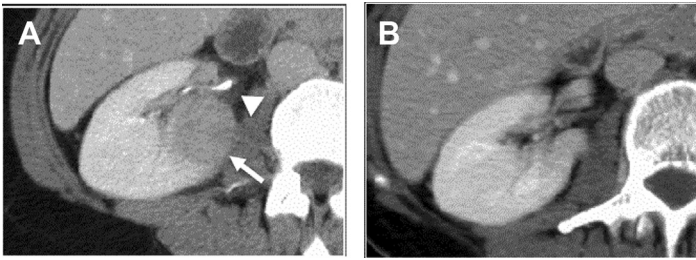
(A) Axial contrast-enhanced CT image in a patient with flank pain shows a focal rounded masslike abnormality (*arrow*) with mild stranding in perirenal fat (*arrowhead*). The mass was initially interpreted as a neoplasm until information about pyuria and fever became available. (B) A follow-up-enhanced CT image obtained 4 months later shows resolution of focal infectious nephritis.
